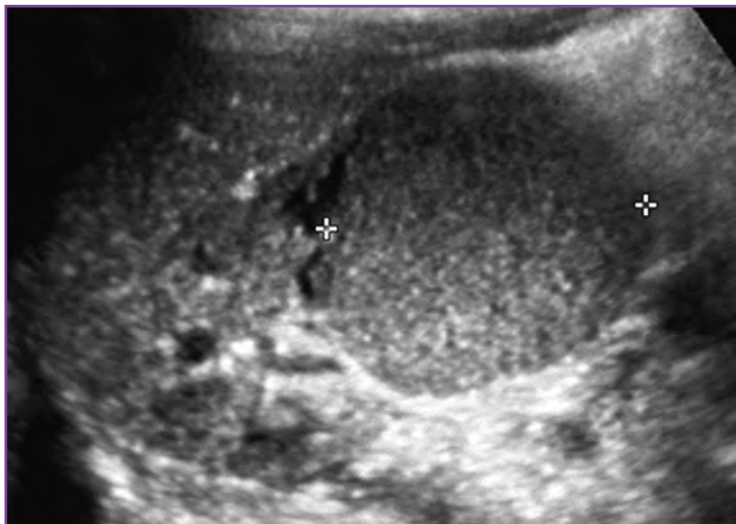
Ultrasonography shows nephroblastoma (Wilms tumor) of the kidney with replacement of normal renal architecture.
